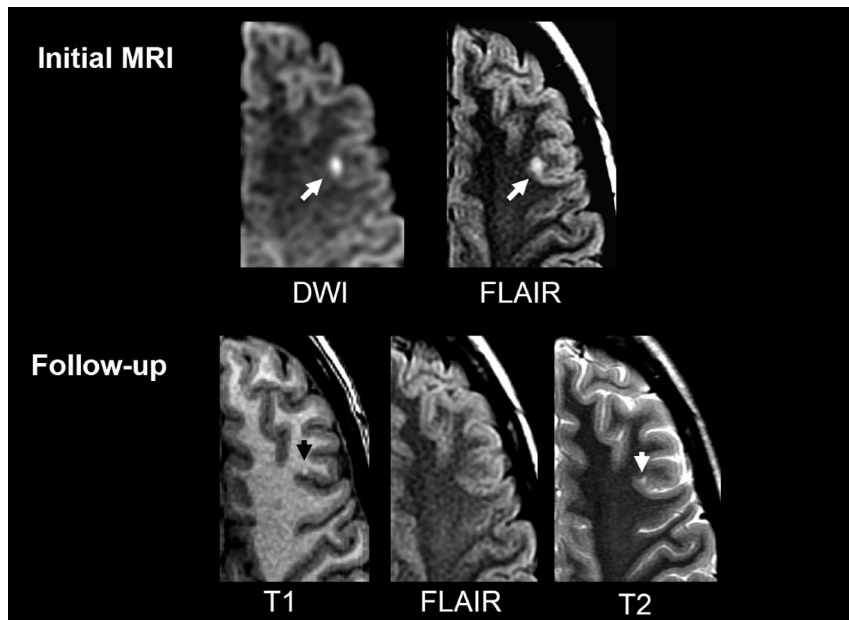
A 21-year-old woman with a right sensory-motor deficit and aphasia for 60 minutes. Initial MR imaging (4 days after onset) shows a punctate cortical DWI/FLAIR hyperintensity in the left superficial middle cerebral artery (MCA) territory. On follow-up MR imaging (15 months after onset), a small permanent injury can be seen as a bright cortical dot on T1-weighted sequence with mild atrophy on T2-weighted sequence. Note that no signal intensity change is seen on FLAIR.
